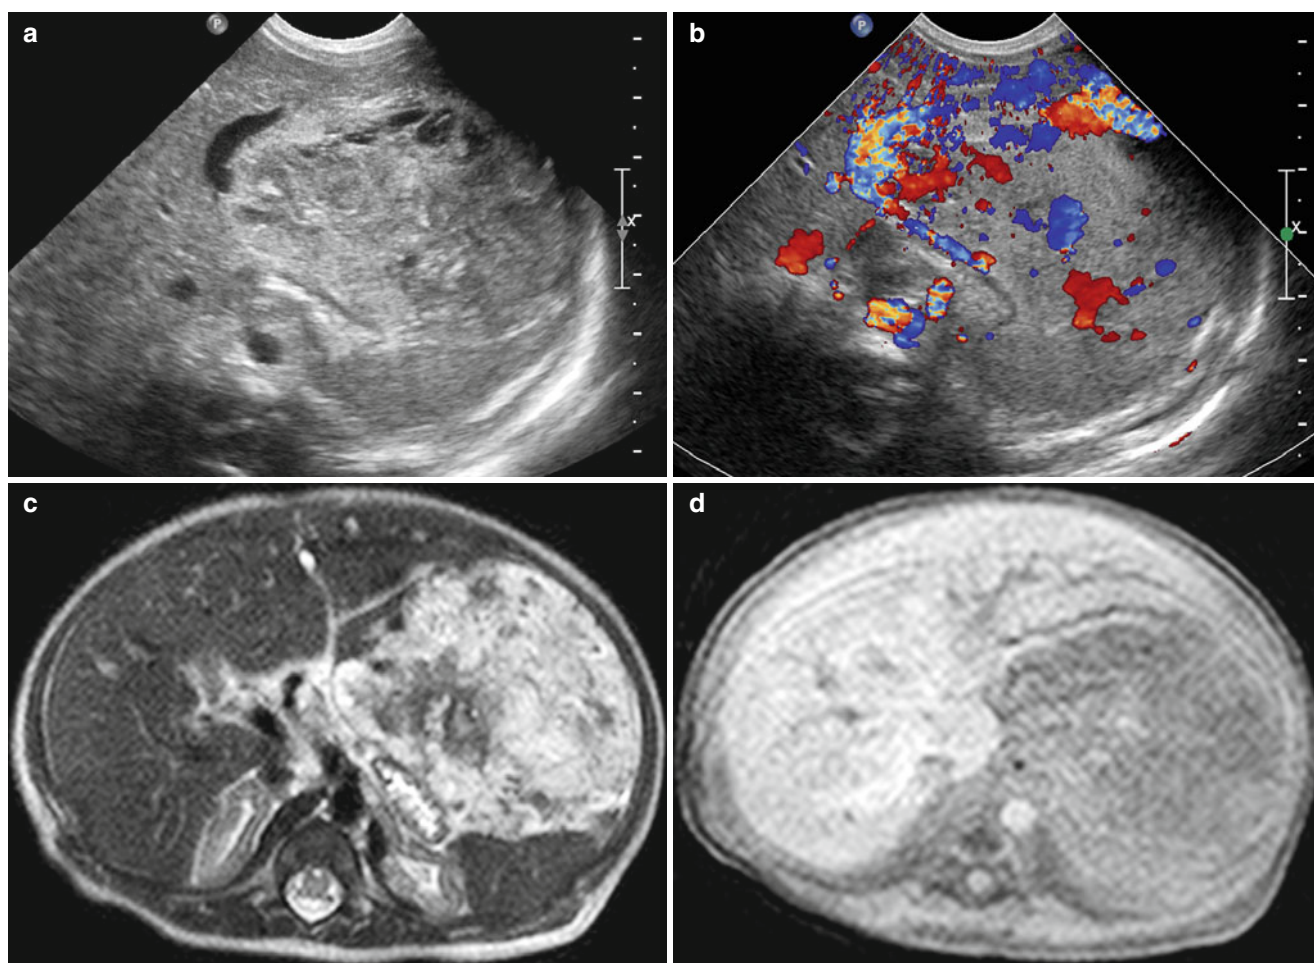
Hepatic hemangioendothelioma in a female neonate. (a) Abdominal US shows huge, heterogeneously hyperechoic mass in left lobe of liver with surrounding engorged vessels. (b) Color Doppler US shows marked increased vascularity in this mass. (c) T2-weighted MR image shows heterogeneously high-signal intensity of this mass. (d–f) T1-weighted images with fat suppression show low-signal intensity mass with internal high signal intensity portion on pre-contrast image (d), intense, nodular peripheral enhancement on arterial phase image (e), and central progression of the enhancement on delayed image (f). Initial AFP level was 35572 IU/mL. (g) Follow-up abdominal US after 2 months shows decreased size of the hepatic mass with decreased echogenicity and increased internal hyperechoic foci suggestive of calcifications
